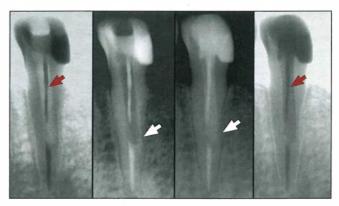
Periapical radiograph showing remaining guttapercha in the prepared post space, which might impair proper bonding of the FRC post (*red arrow*), and deviation of the canal post space due to the original canal direction and incorrect pilot bur angulation and size (note the reduced root dentin thickness—*white arrow*).
